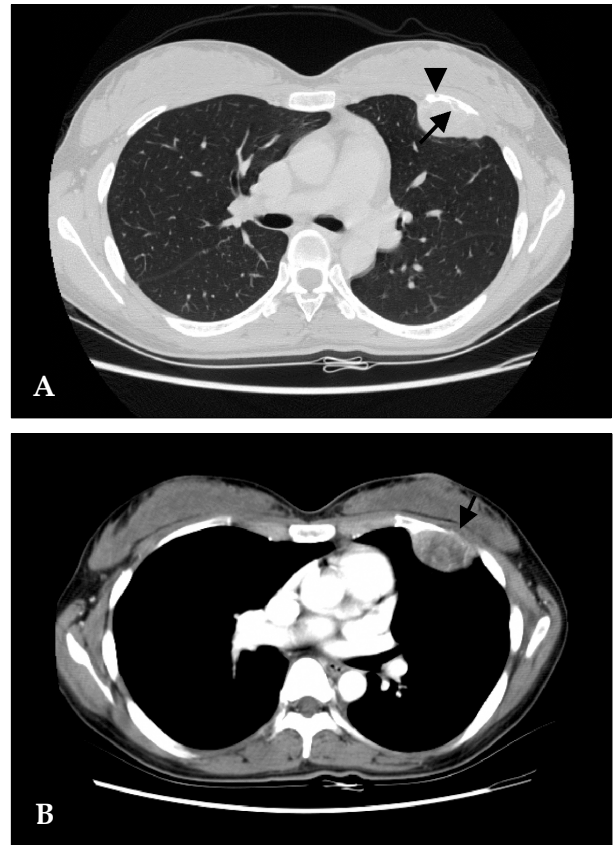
CT demonstrated the presence of a relatively well defined, ovoid shaped mass at the anterior chest wall. A. Bony infiltration (arrow) and defect (arrowhead) was suggestive of the tumor having a malignant nature. The interface between the mass and the lung was smooth, and compression of the lung was observed. B. The mass showed heterogeneous weak enhancement (arrow). There was no mediastinal lymph node enlargement.
